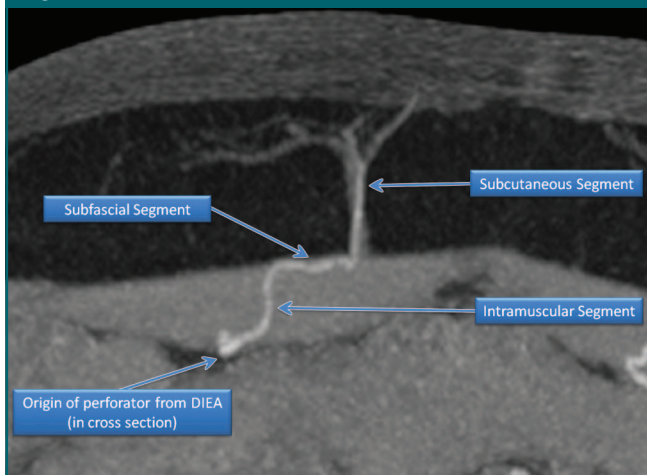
Axial 50-mm section thickness maximum intensity projection (MIP) image obtained with abdominal wall CT angiography shows the labeled segments of a perforator originating from the right DIEA.
